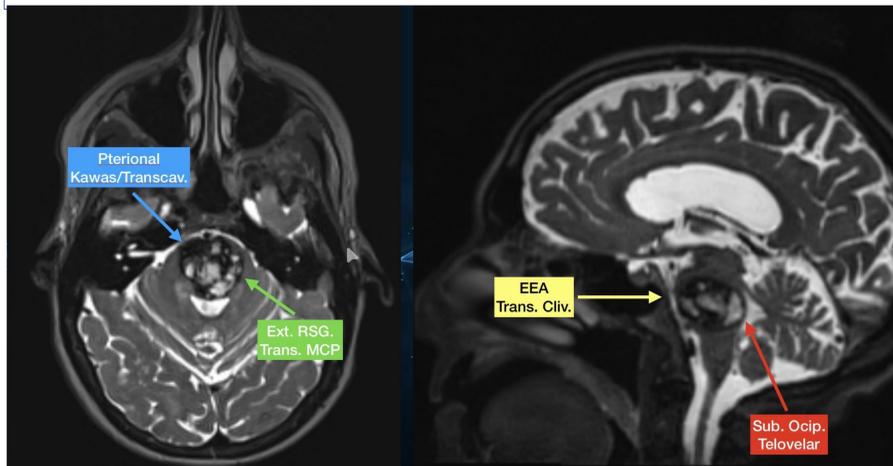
MRI Brain T2 weighted axial and sagittal views demonstrating a large left eccentric central pontine cavernous malformation with mixed density and a hemosiderin ring. There is effacement of the pontine structures. Operative Approaches that were considered include pterional with a kawasi approach, endoscopic endonasal trans clival approach, sub occipital telovelar approach, and extended retrosigmoid approach with trans middle cerebellar peduncle (MCP) approach. The extended retrosigmoid trans. MCP was selected due to reduced risk of morbidity and traverses least amount of eloquent pontine tissue.
